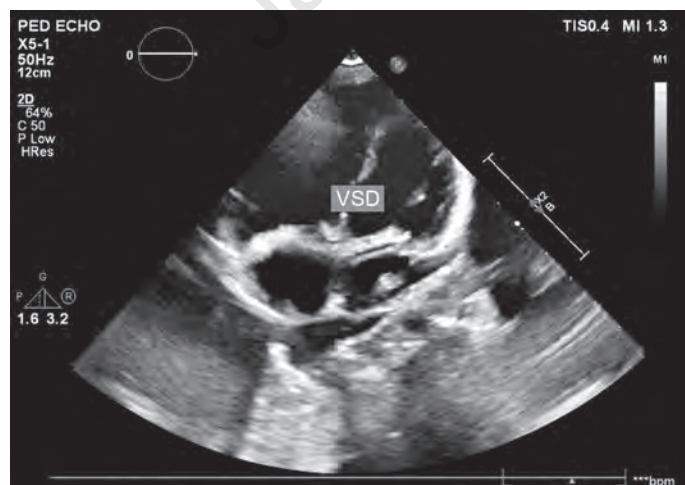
D-TGA: Apical four-chamber view showing VSD.
